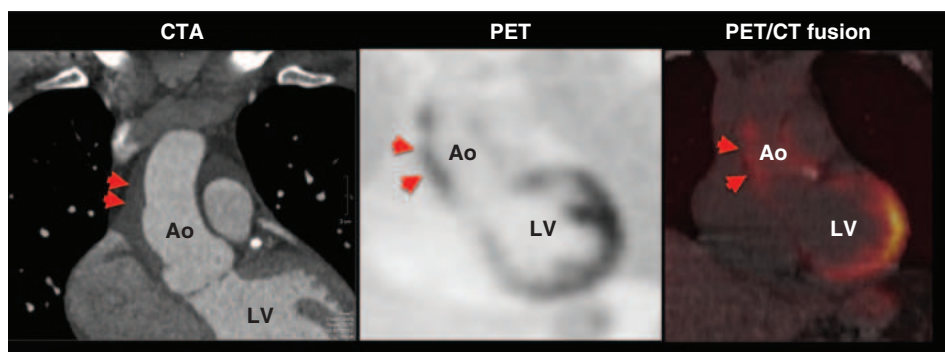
Representative coronal computed tomography (CT) angiographic (CTA; *left panel*), fluorodeoxyglucose (FDG) positron emission tomography (PET; *middle panel*), and fused CT and PET (*right panel*) images in a patient with suspected aortitis. The CTA images demonstrate thickening of the ascending aorta (Ao), which correlates with intense, focal FDG uptake consistent with active inflammation. LV, left ventricle.
